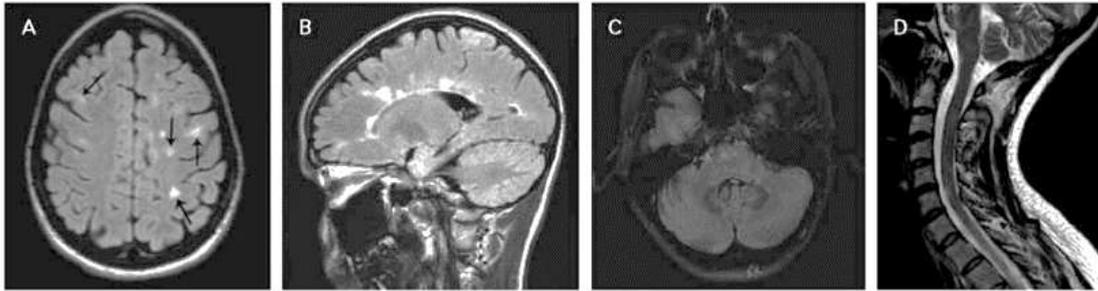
Brain MRI patterns in patients with CIS.
